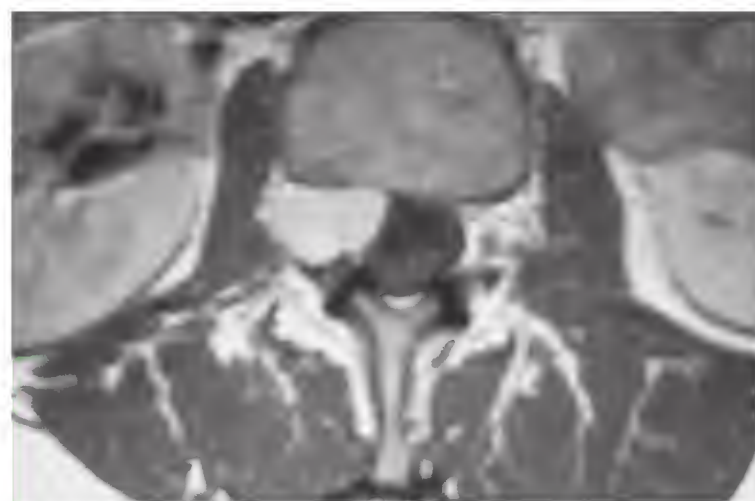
Neurofibroma. A transverse T1-weighted magnetic resonance image following intravenous gadolinium administration shows an enhancing mass occluding the right neural foramen of L2. Note how local bone erosion has widened the neural foramen.
